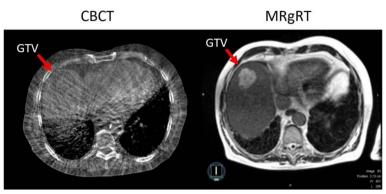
Thoracic cone-beam CT (CBCT) image (left) compared to a contrast-enhanced T1-weighted MR image, demonstrating better identification of a liver tumour (hepatocellular carcinoma, red arrow) within the gross tumour volume (GTV) (Reprinted from Mittauer et al. (2018), licensed under the Creative Commons Attribution License)
